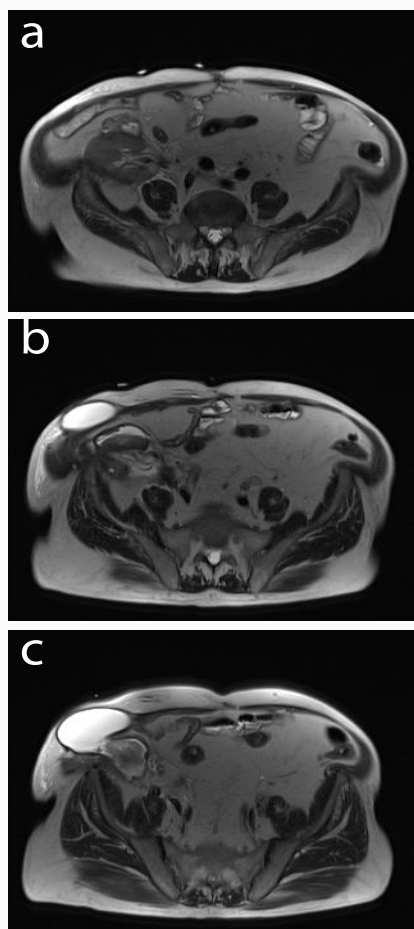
Magnetic resonance imaging: Multiple cranio-caudal sections.
